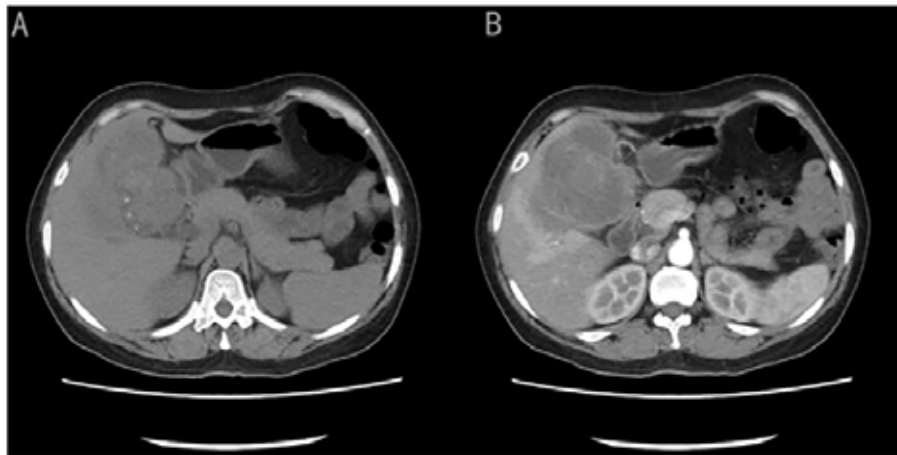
(a-b): Gallbladder carcinoma presenting as a mass lesion in a 68 years male, (a) Axial CT shows an irregular gallbladder with a mixed hypodense mass, (b) Contrast-enhanced CT showing heterogeneous enhancement of the mass
